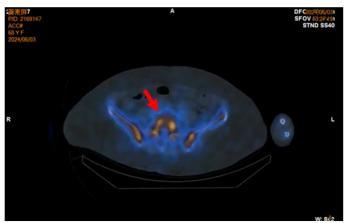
Skeletal scintigraphy with hybrid images of SPECT/ *CT* of the patient's spine. (A) *CT* scan films of the pathologic lumbar facet joints and both sacroiliac (SI) joints. (B) Bone scan images with noticeable pathologic spine in black. (C) SPECT/CT image with significantly increased bone turnover at the the lumbar facet joints and both sacroiliac (SI) joints.
